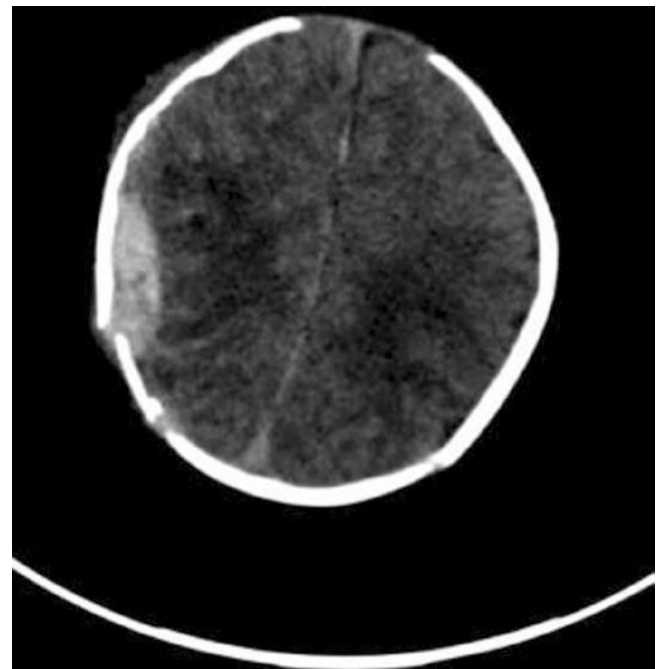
Axial CT image shows an acute extradural haematoma complicating a right parietal bone fracture
